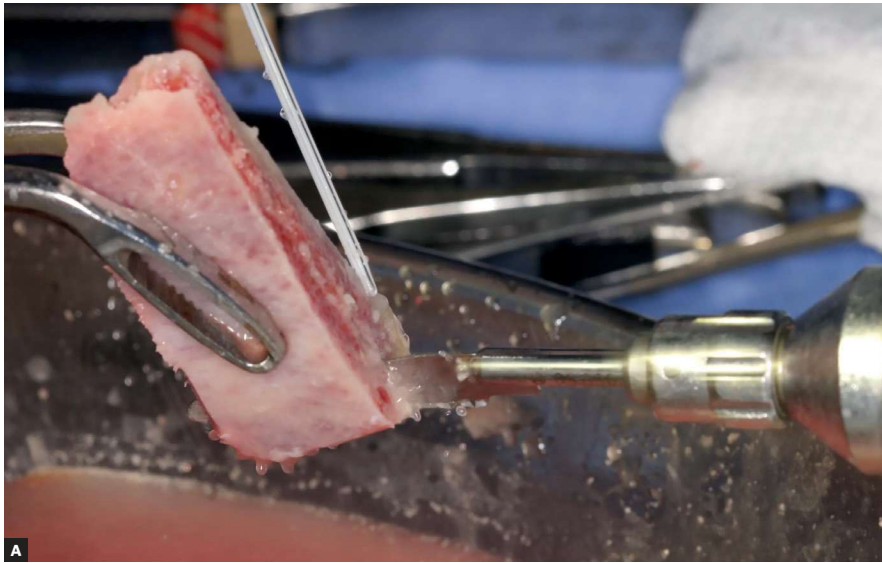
A) Preparation of corticomedullary blocks transoperatively. B) Fixation of blocks using bicortical screws and titanium plates with two orifices. C) Cone-beam computed tomography obtained four months after reconstruction with bone graft from the iliac crest.
